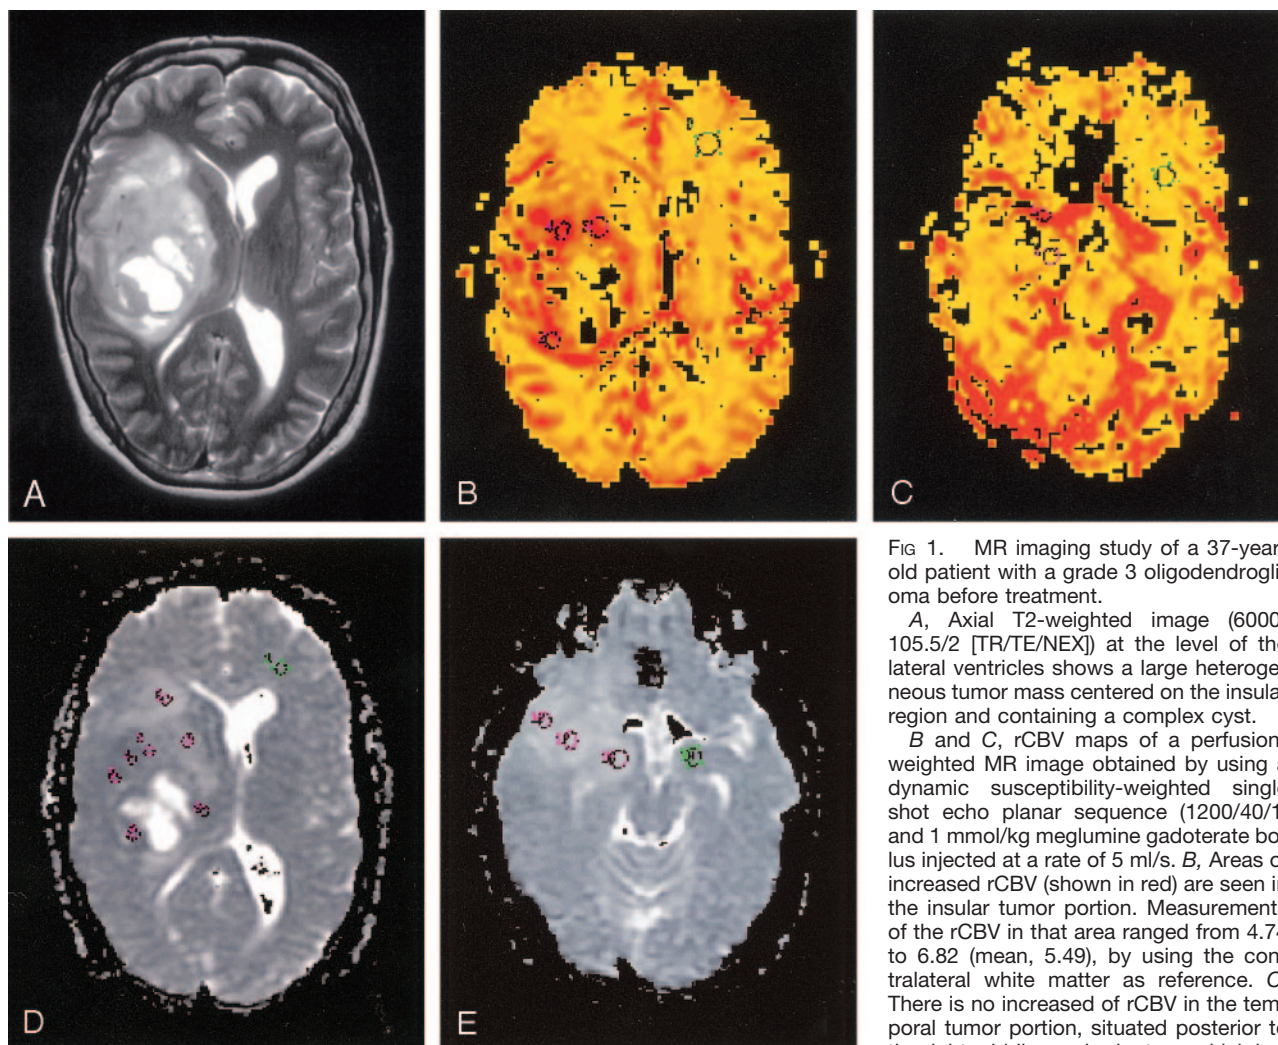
MR imaging study of a 37-year-old patient with a grade 3 oligodendroglioma before treatment.
